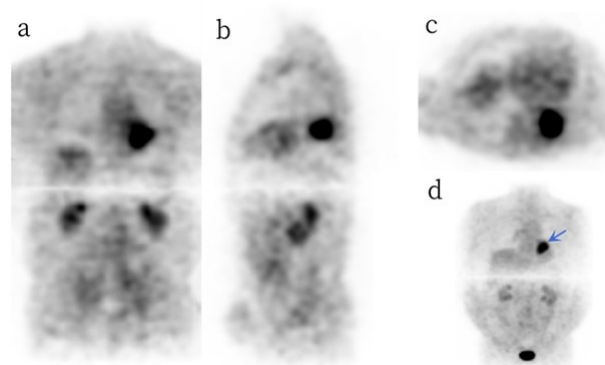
Representative coronal(a), vertical(b), and transaxial (c) positron emission tomography (PET) images of a patient with small-cell lung cancer showing automatically identified the region of interest (ROI) for calculating SUV.
